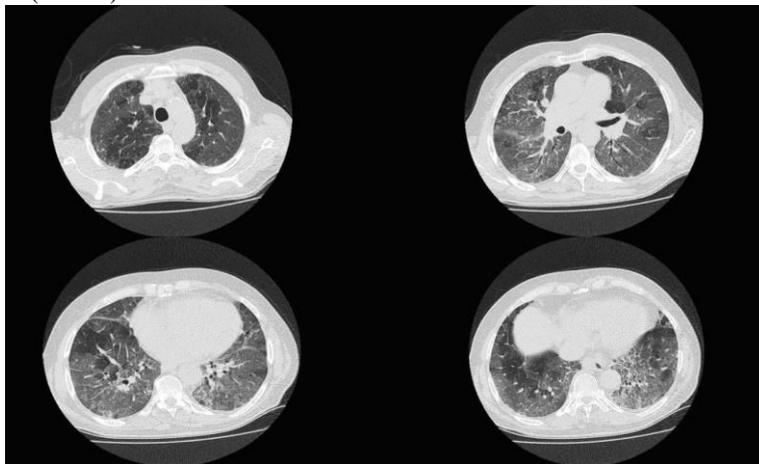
Thoracic CT images taken during the first hospitalization due to COVID-19 pneumonia, showed bilateral disseminated ground glass areas and normal mediastinal pathology.
